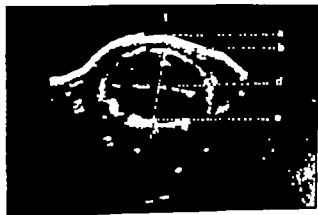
Fetal head cross sectional display on ultrasonic B-Scan screen (a, b, d see Fig. 3).
